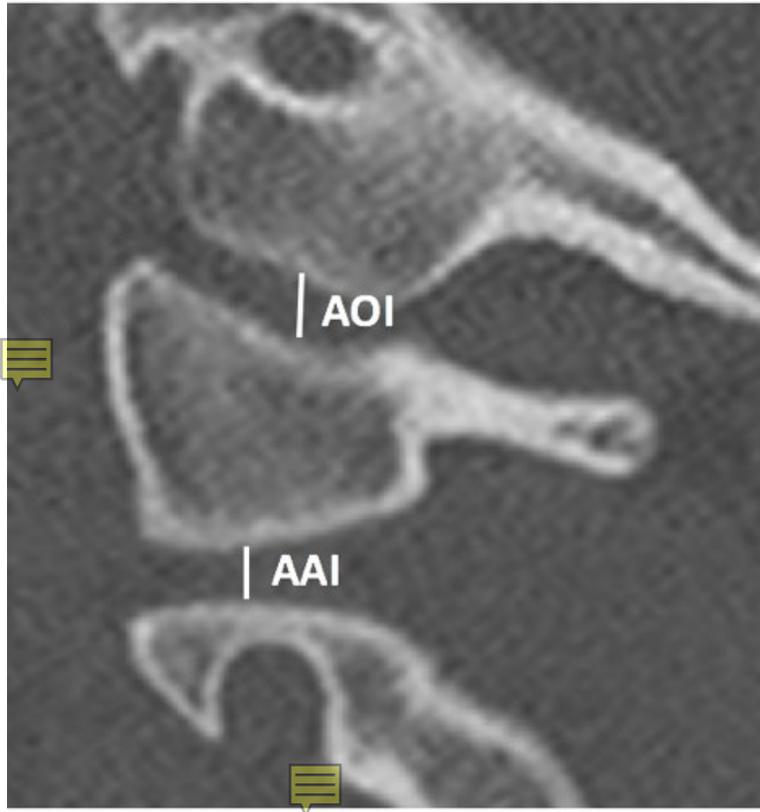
Sagittal cervical spine CT image demonstrating AOI and AAI measurements
